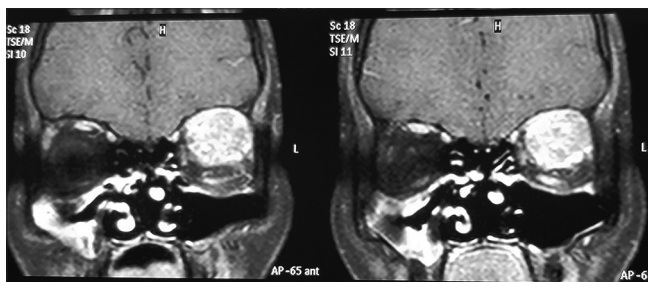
Coronal magnetic resonance image obtained in the plane of the left globe shows a large lesion occupying most of the left orbit with heterogeneous enhancement on contrast administration. The left globe is proptosed and is not seen on this image
